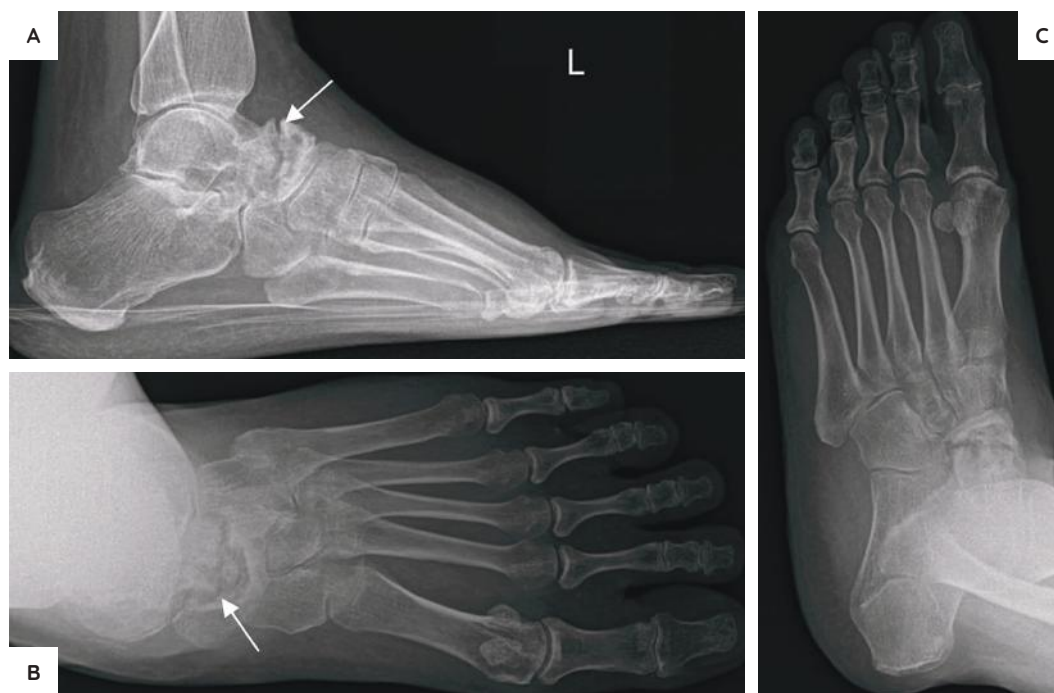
Preoperative radiographs [lateral view (A), anteroposterior view (B), oblique view (C)] of the left foot showing cortical irregularities with sclerotic changes (white arrows) of the talus and navicular bones with apparent narrowing of the talonavicular joint.
